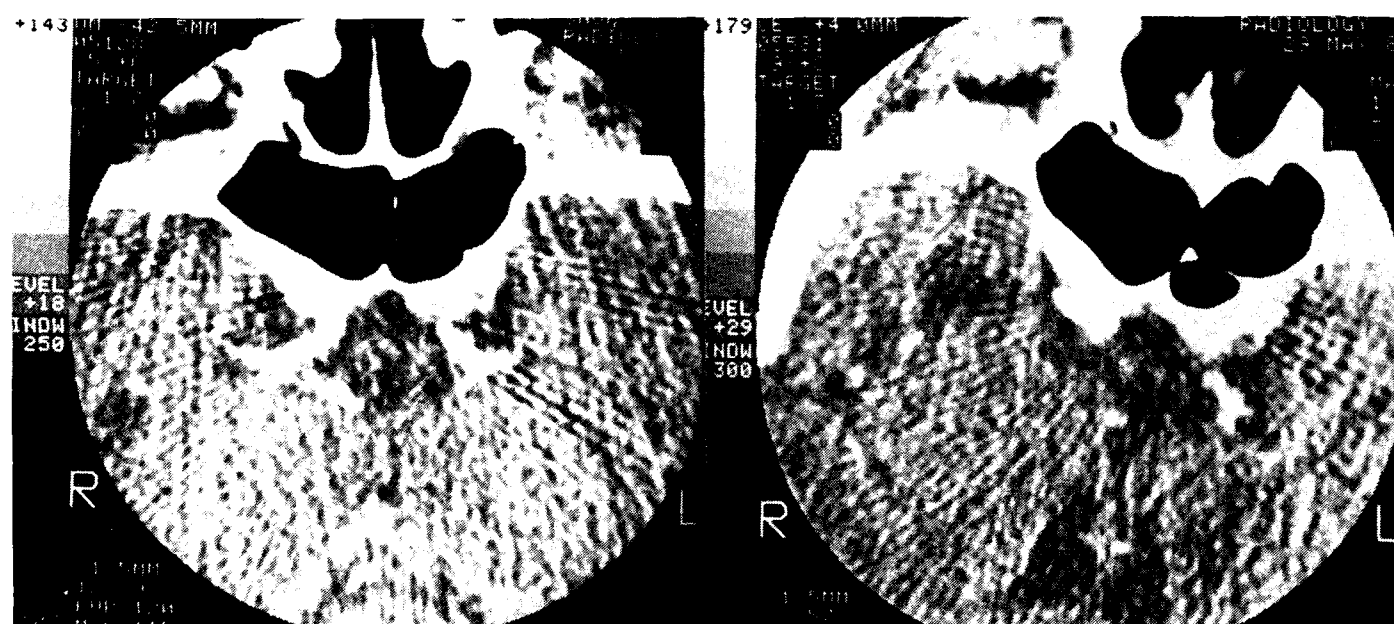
Sella CT showing partial empty sella (Rt on 29th and Lt on 66th day of illness).
